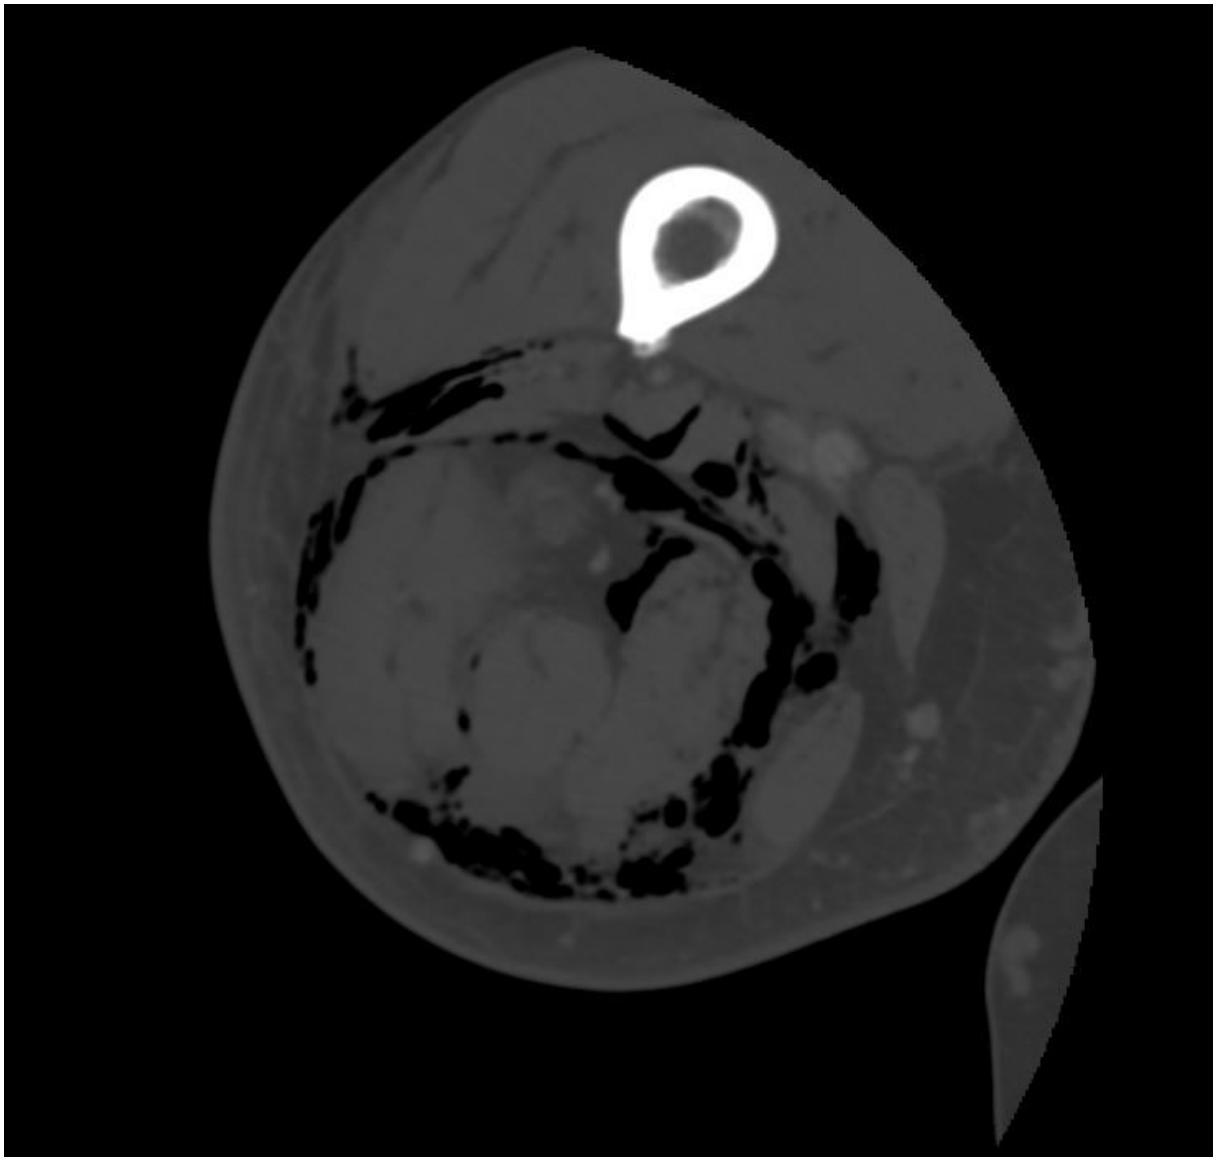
Contrast-enhanced CT of the upper leg, axial plane.
